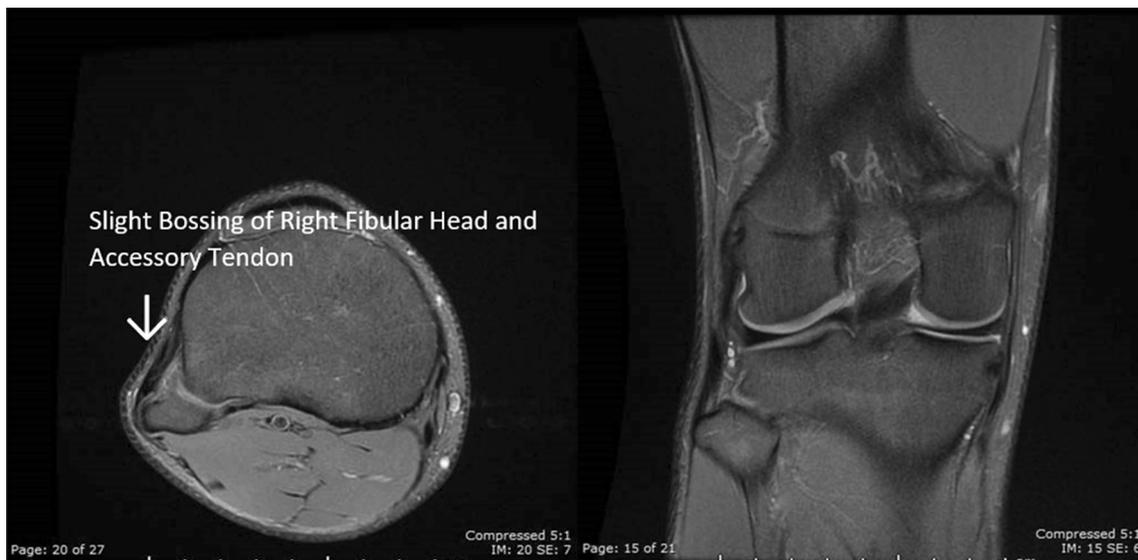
Magnetic resonance images of the right knee in coronal and transverse plains revealing slight fibular bossing and accessory band of the biceps femoris tendon
